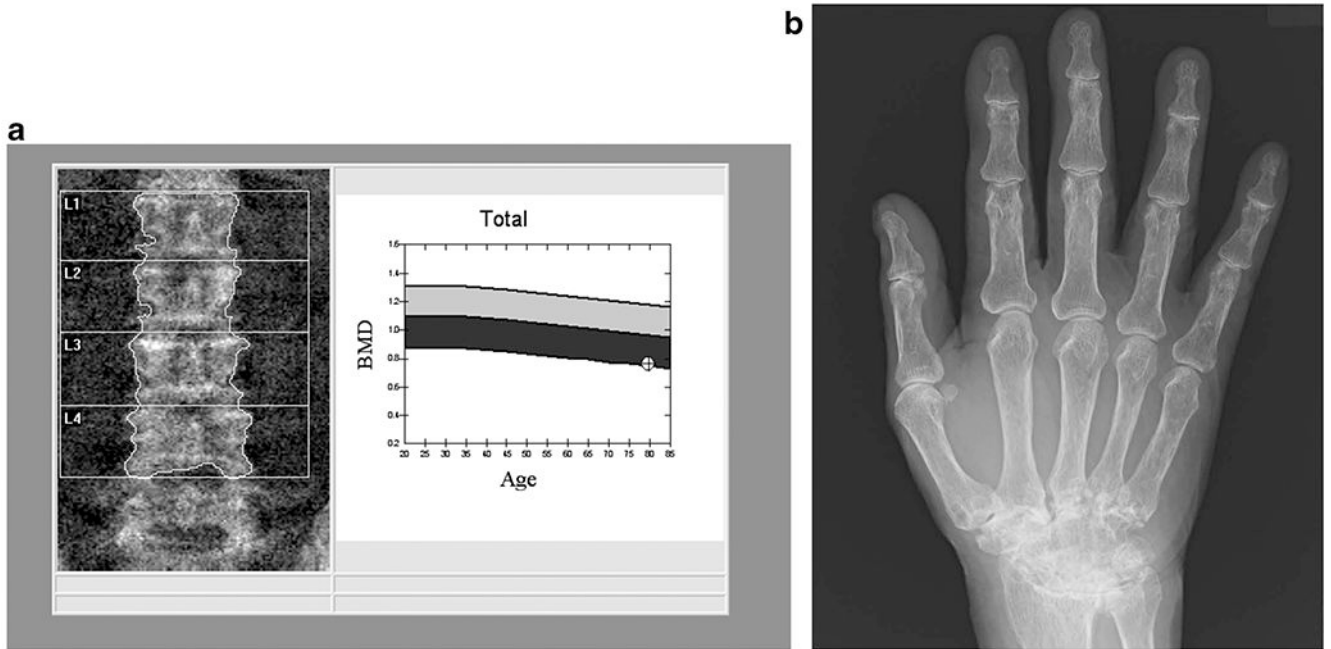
79-year-old man with a 25-year history of rheumatoid arthritis (RA). The DXA image of the lumbar spine (a) shows mild multilevel degenerative changes. A BMD of 0.762 g/cm² was measured, which corresponds to a T-score of – 3.0. The radiograph of the right hand (b) shows advanced fusion of the carpal bones consistent with the long history of RA
